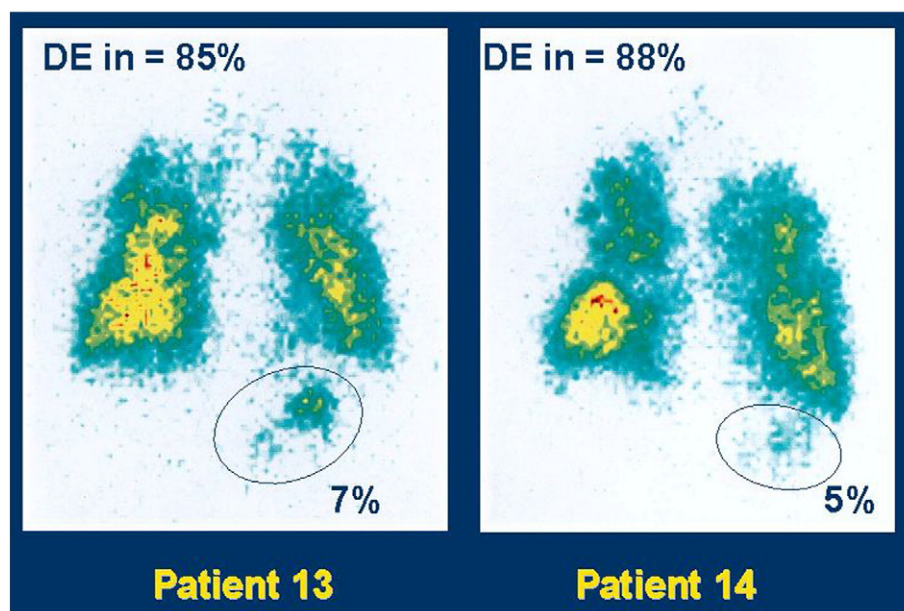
Gamma scintigraphic images of two CF patients following administration of ^{99m}Tc labeled iron oxide particles with the AKITA nebulizer device. The AKITA controls the flow of medication from the device to maximize the efficiency of delivery to the lungs. For the two patients shown, 85% and 88% of the delivered dose is deposited within the lungs [107].
